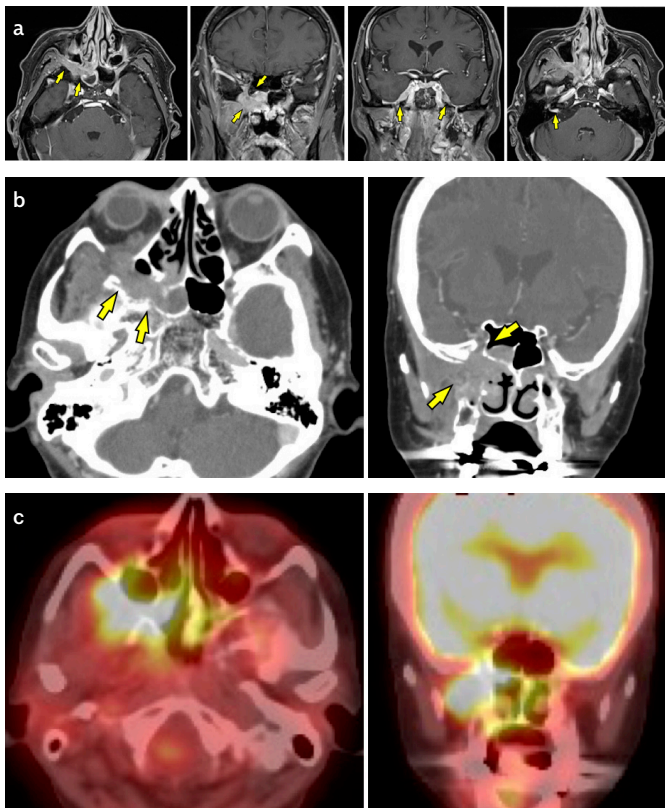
a-c. Contrast-enhanced MRI and CT showing lesions infiltrating Meckel's cavity and the cavernous sinus from the right PPF and an expanding foramen rotundum (arrow). Contrast-enhanced effects are observed in the area along the skull base on both sides of the cavernous sinus and around the facial nerve, predominantly on the right side (a, b). Bone destruction and osteosclerosis are observed in the surrounding bones, including the sphenoid bone. FDG-PET shows FDG accumulation consistent with the PPF lesions (SUVmax 8.2), but no other lesions (c).
